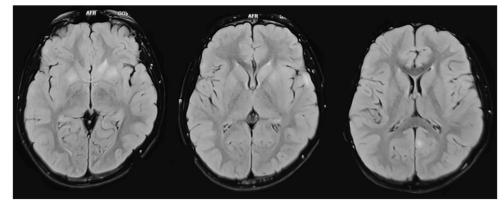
T2 FLAIR image shows hyperintensities in bilateral cerebral cortex (left more than right) and basal ganglia
